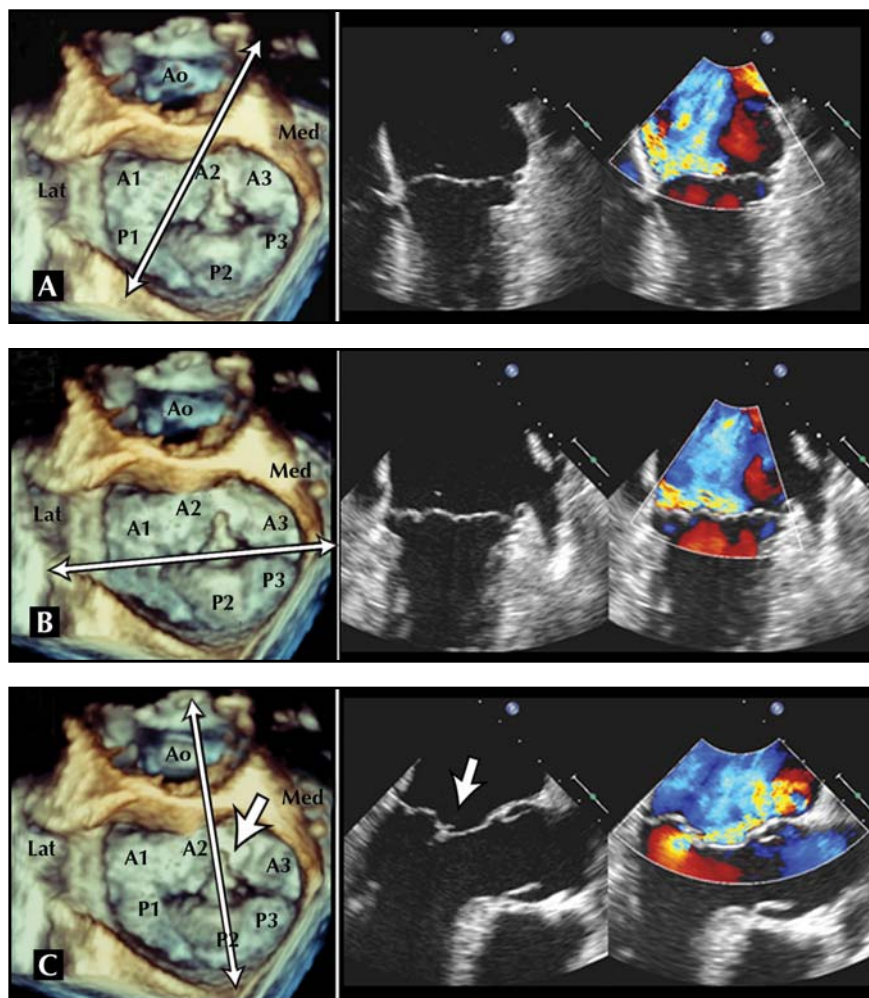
Example of a patient with a type II – P2 degenerative mitral valve disease due to fibroelastic deficiency. A, Four-chamber view obtained at 0° depicting A2 on the left and P2 on the right. B, Two-chamber view obtained by rotating the transducer to 90° to visualize P3 on the left and the three scallops of the anterior mitral valve leaflet on the right. C, Long-axis view obtained by further rotating the transducer to 120° to view the flail P2 segment (*small arrow*) on the left and A2 on the right. The direction of the color jet in the long-axis view (*bottom left*) is away from the side of the lesion. The images in the left column correspond to the surgical mitral valve image (as visualized from the left atrial perspective) obtained using real-time three-dimensional matrix-array transesophageal echocardiography (TEE) volume rendering. The *long arrows* represent the approximate cut planes from which the respective two-dimensional TEE images were obtained. A1, A2, A3—scallops of the anterior mitral valve; Ao—aorta; Lat—lateral; Med—medial; P1, P2, P3—scallops of the posterior mitral valve.
